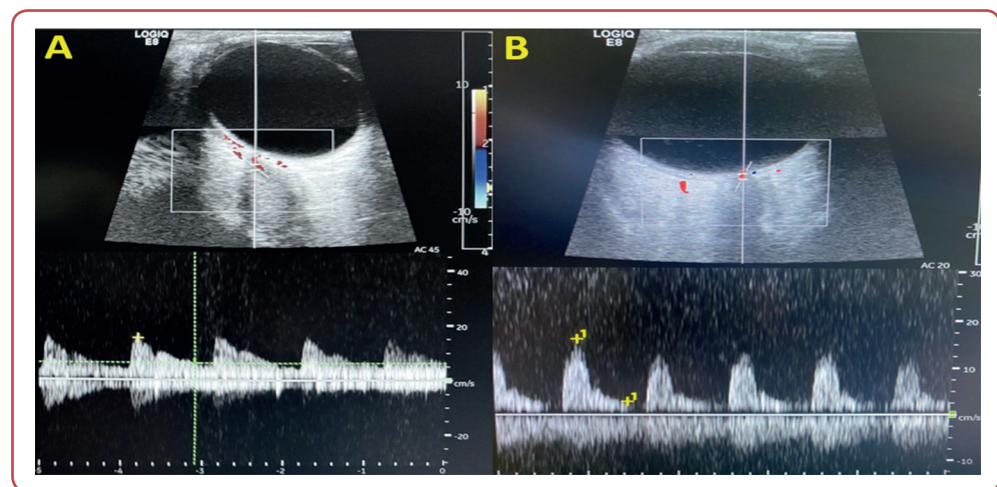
Pulsed wave ultrasound. A) Control group shows low resistance flow through the central retinal artery, RI = 0.6. B) hypertensive group, show high resistance flow through the central retinal artery, RI = 0.8.
